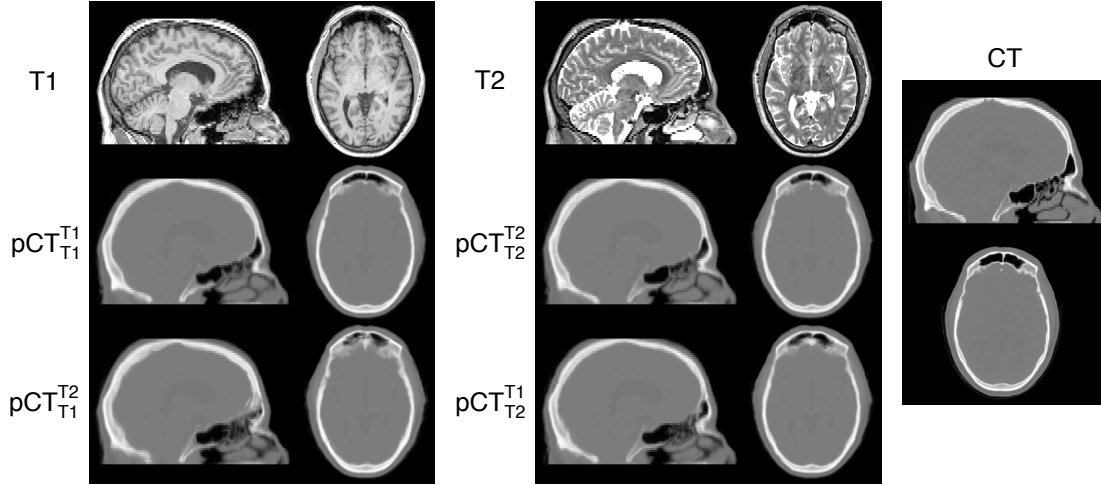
Example of pseudo CTs synthesised from a T1-w MR image using the T1/CT database (pCT_{T1}^{T1}) and the T2/CT database (pCT_{T1}^{T2}), and from a T2-w MR image using the T2/CT database (pCT_{T2}^{T2}) and the T1/CT database (pCT_{T2}^{T1}).
